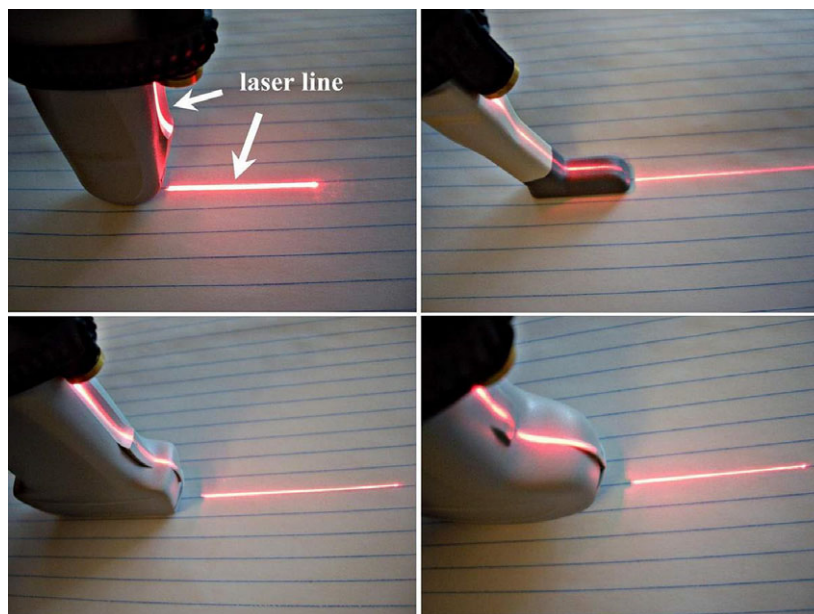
Example of a laser guide attached to an ultrasound probe (Image courtesy of Regional Anesthesia and Pain Medicine through Copyright Clearance Centre license number 3951950371101).
